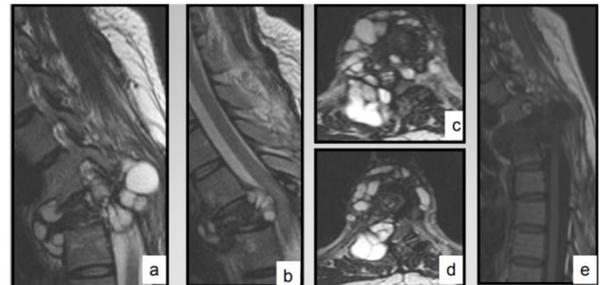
MRI of the dorsal spine: sagittal (a, b) and axial sections in SPT2 (c, d), sagittal section in SPT1 (e): Multiloculated cystic formation of D4 and D5, with hyposignal T1, hypersignal T2 content; partitions in hyposignal T1 and T2. It is responsible for vertebral compression of D4, extends to the spinal canal, pushes backwards and compresses the spinal cord with signs of spinal cord injury. It also extends to the pre- and retrovertebral soft tissues
